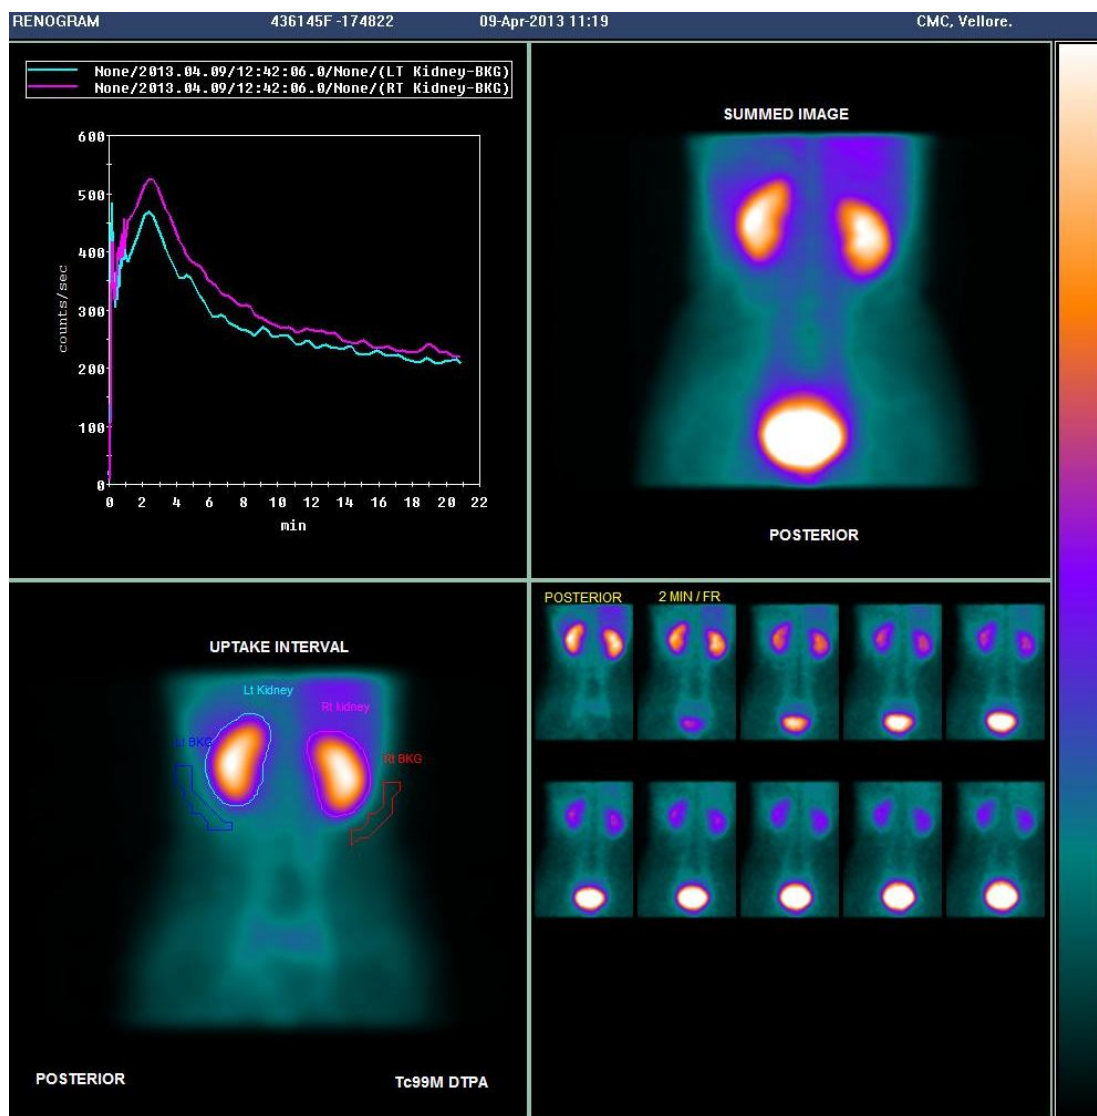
Tc99m DTPA renal scintigraphy showing almost equal function of both the kidneys.
